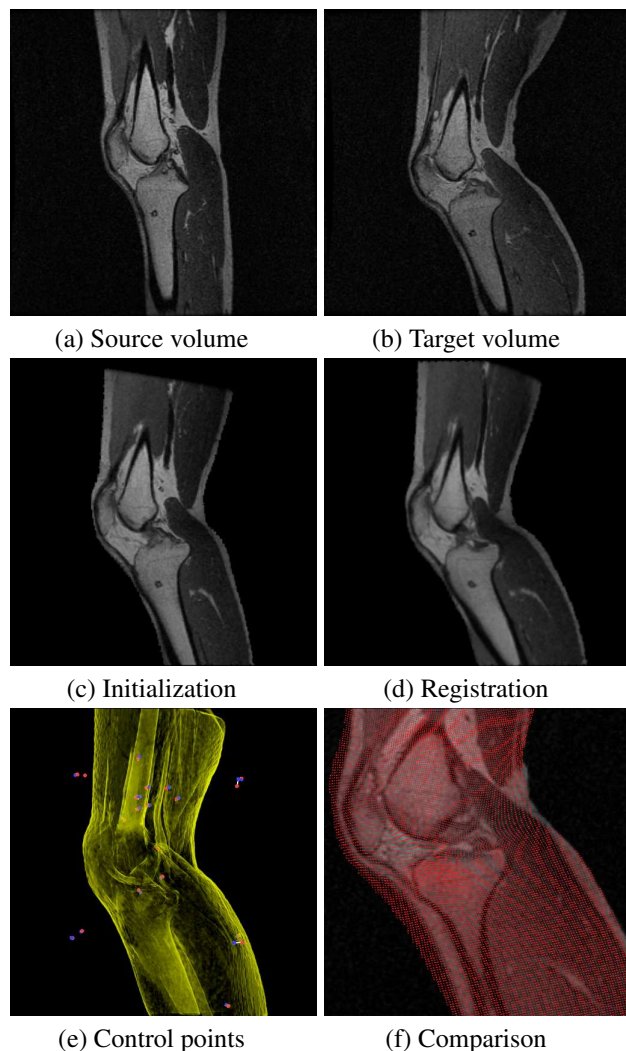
3D registration of real 3D MRI knee scans.
